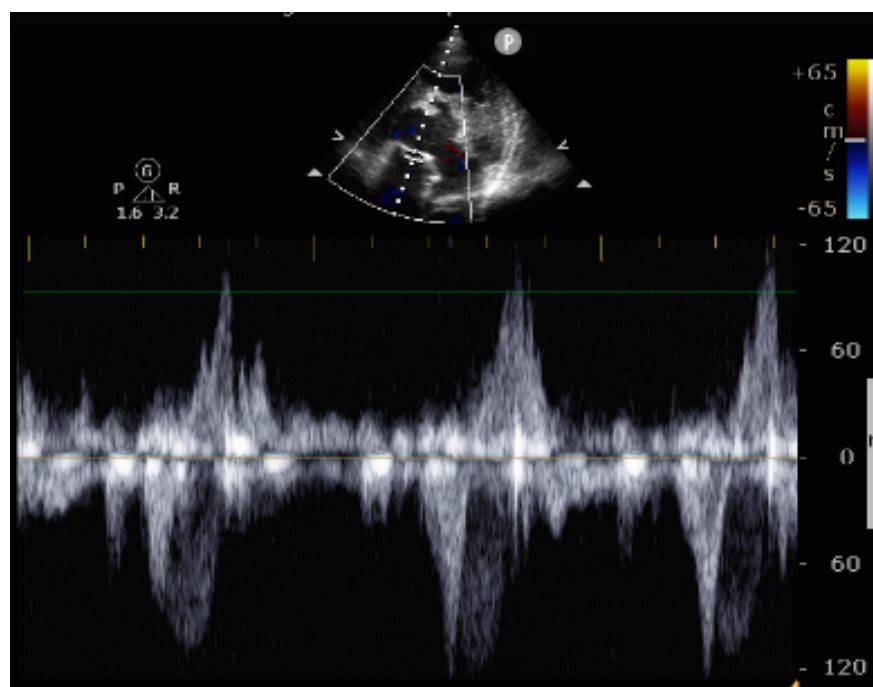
A-C, parasternal long axis and short axis view revealed a cystic cavity, located in the interventricular septal extending from the basal anteroseptum to anterior wall of the left ventricle, within it, a string-like echo is visible. D-F, color doppler and pulse wave doppler revealed that the cystic cavity communicated with aortic root aneurysm through the orifice (as the arrow indicates), and bidirectional blood flow was visible at the orifice. (LA, left atrium; LV, left ventricle; AO, aorta; PS, pseudoaneurysm; IVS, interventricular septal)
